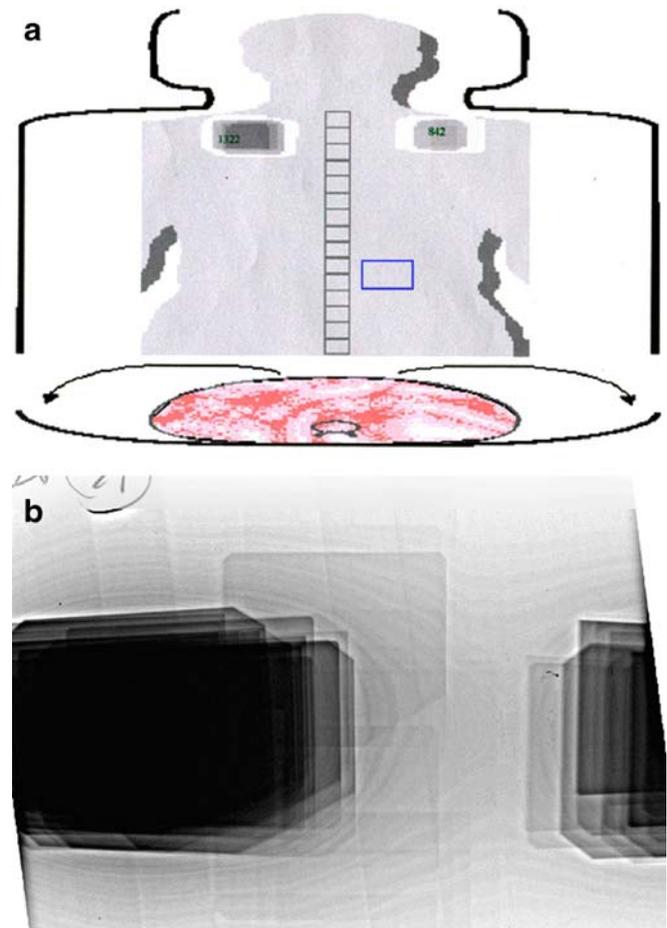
Dose distributions from a dose mapping system (a) and from radiographic film (b). Procedure is a RF cardiac catheter ablation using 51 min of fluoroscopy. Both data sets were obtained simultaneously. The value and location of PSD are displayed. The open rectangle displays the current location and size of the X-ray beam (courtesy of Peter Kwan, Ph.D.)
